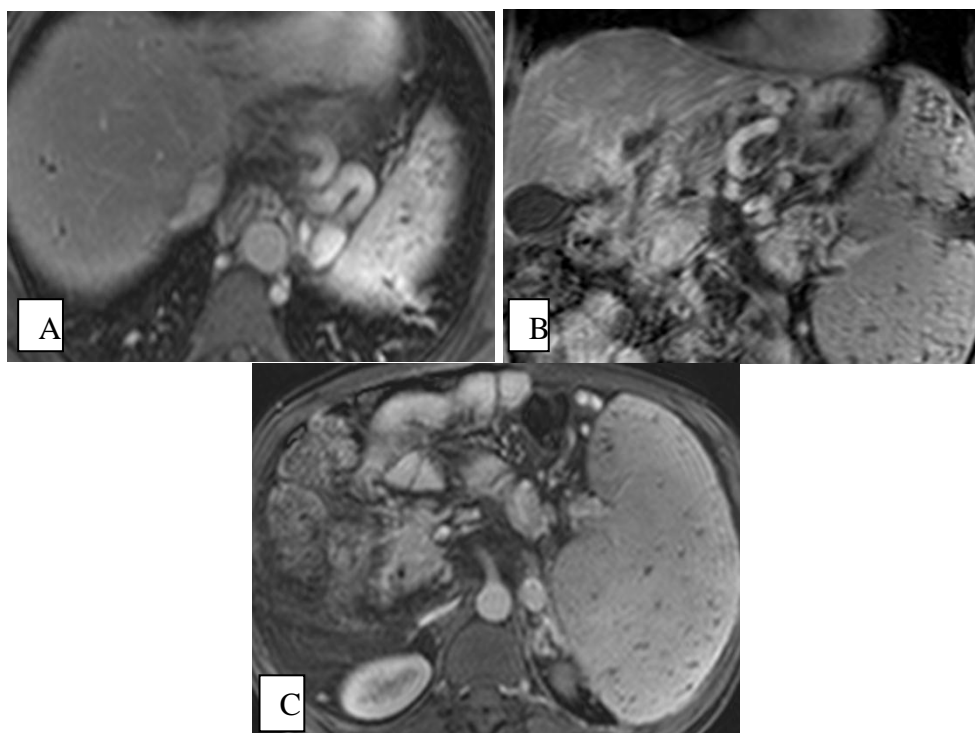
Respiratory gated DCE-MRI (dynamic contrast enhanced) abdomen axial images reveal esophagogastric varices with inflow being from left gastric vein (which ms 9 mm) and outflow being lienorenal collaterals.
